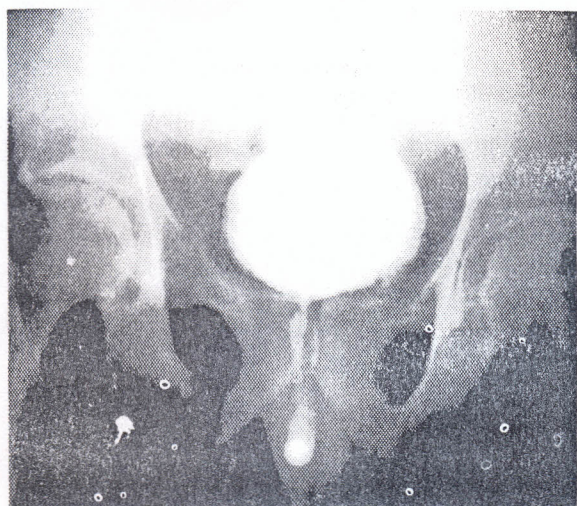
Radiograph of a micturating cysto-urethrogram following removal of the urethral catheter in the same patient. This shows free flow of contrast in a normal caliber posterior urethra.
